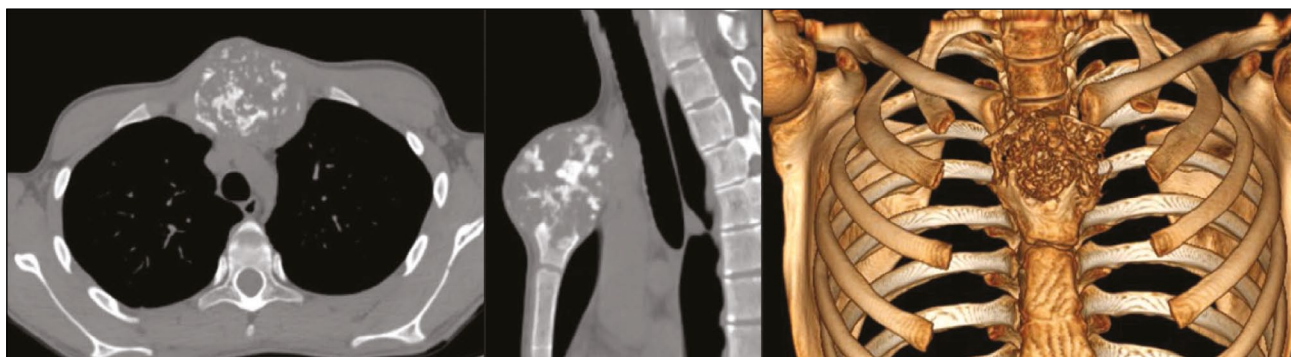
Computed tomography image of the manubrium of the patient G.
